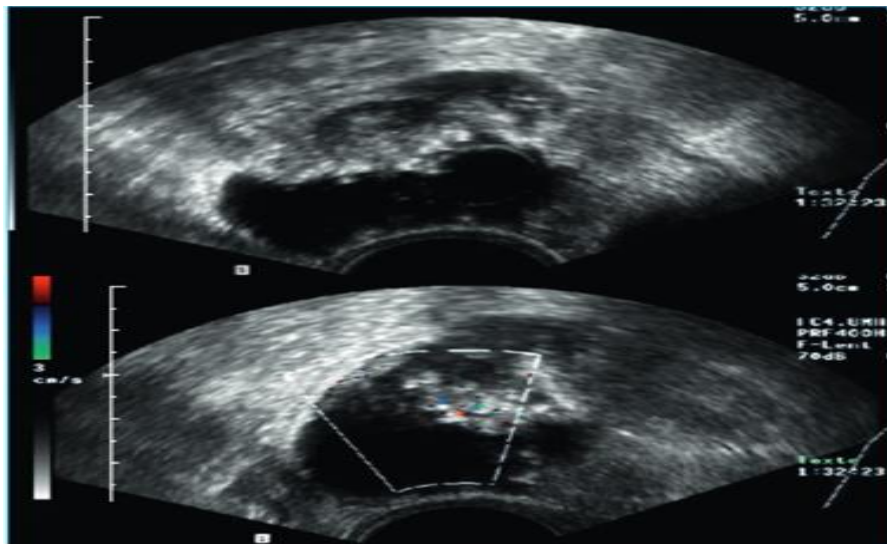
Ultrasound Appearance of an Ovarian Cystadenofibroma.
